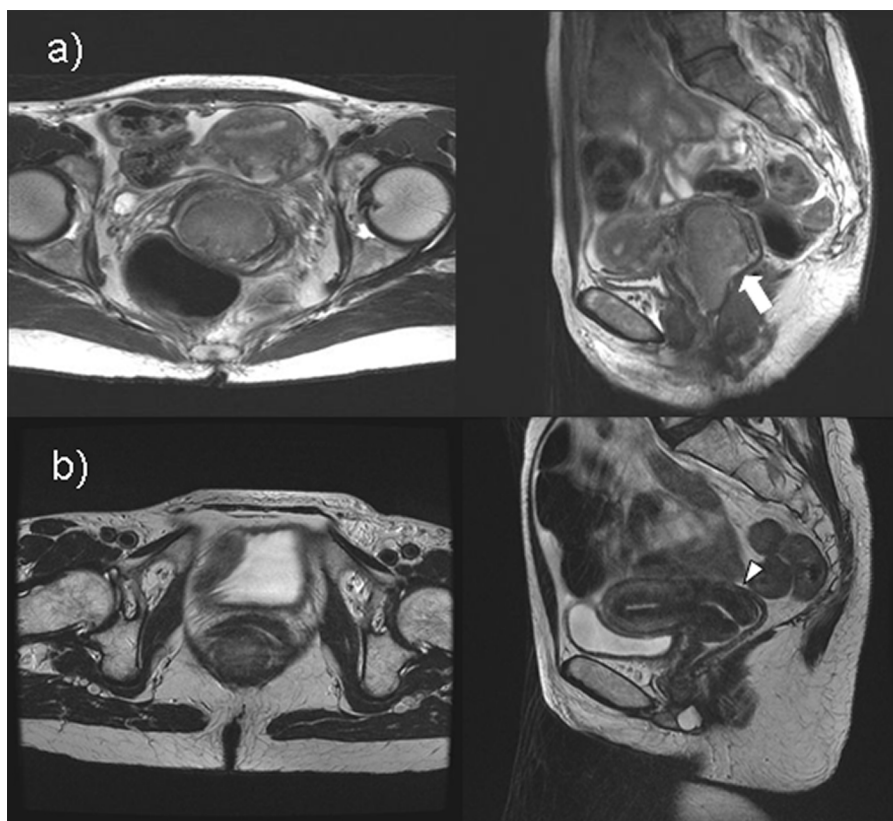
MRI shows a patient in whom physical examination and imaging test is not consistent. (a) Para-axial and sagittal MRI diagnosis. Bulky cervical tumor sample occupies 2/3 of vagina without infiltrating it. No parametrial infiltration. (b) Para-axial and sagittal MRI after treatment, showing persistent hypointense image in the cervix, which is classified as a partial response. However, the physical examination reported complete response.
